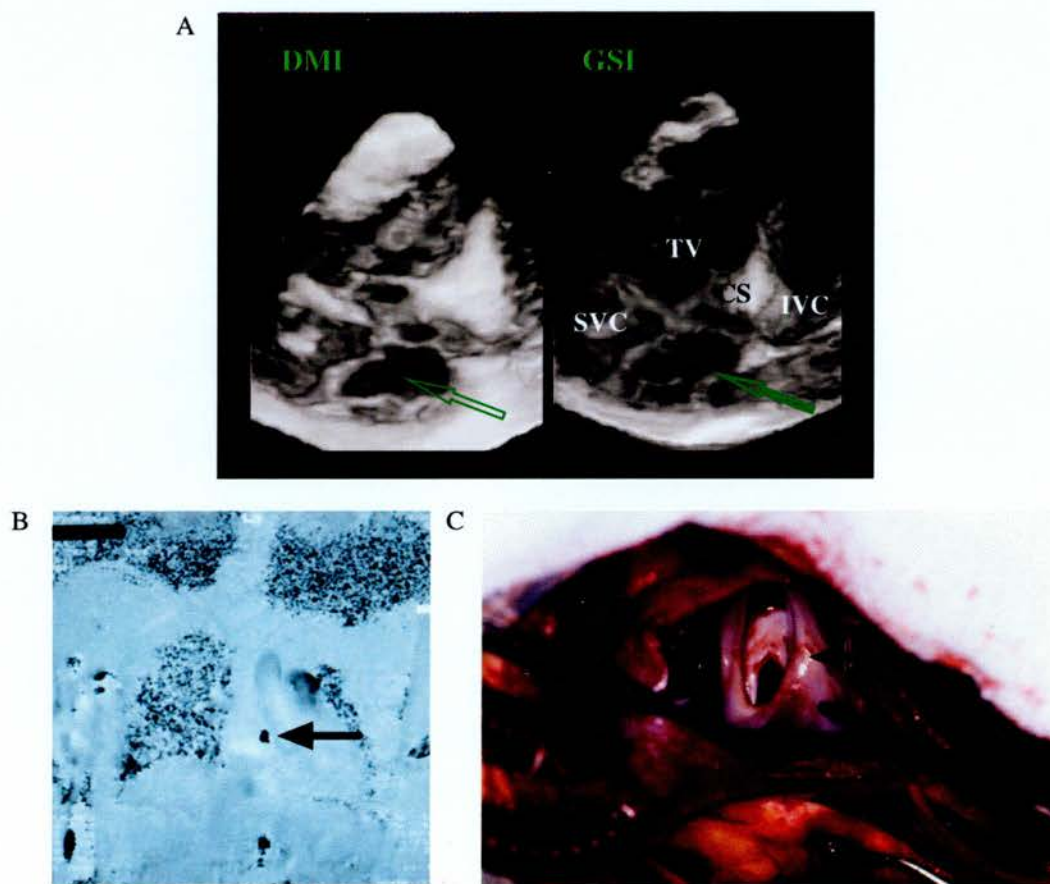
This shows the maximum orifice of an atrial-septal defect as defined by three-dimensional echocardiography (A); phase-contrast cine MRI (B); and surgery (C); For abbreviations see Figure 1. DMI, Doppler myocardial imaging; GSI, grey-scale imaging
